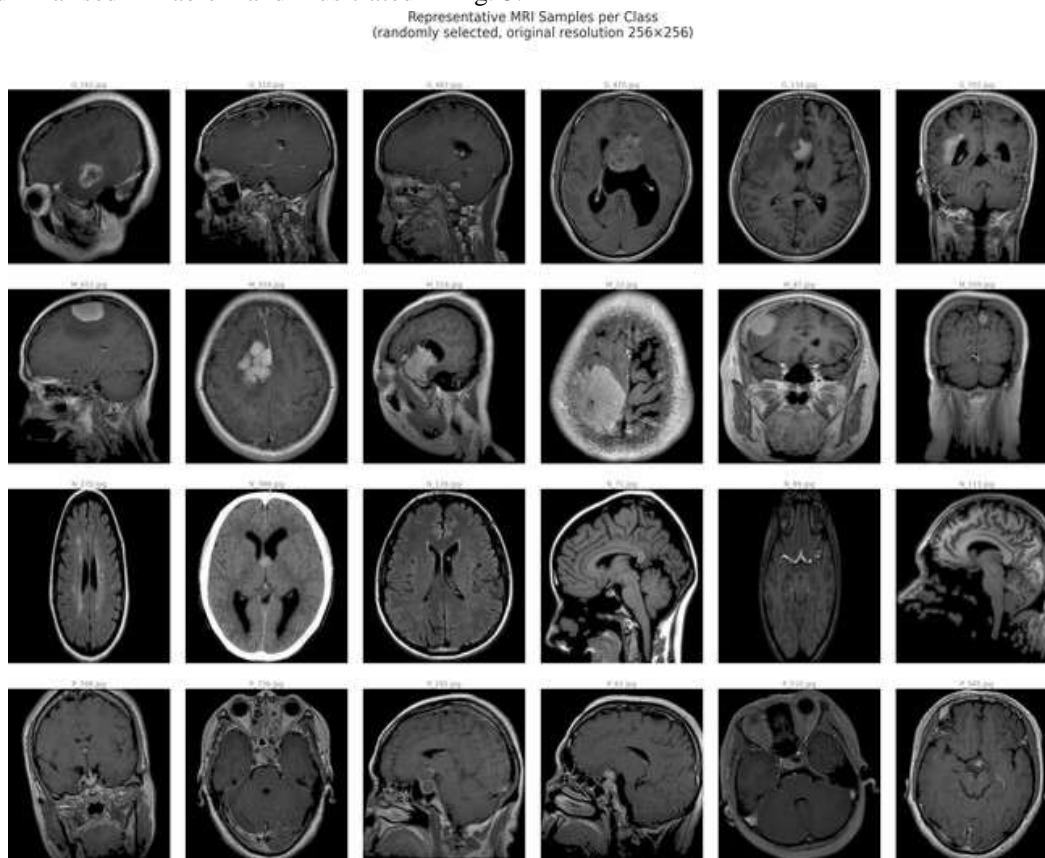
Representative MRI samples per class from the Daneshmand dataset. Six randomly selected images shown per class at original  $256 \times 256$  resolution.
